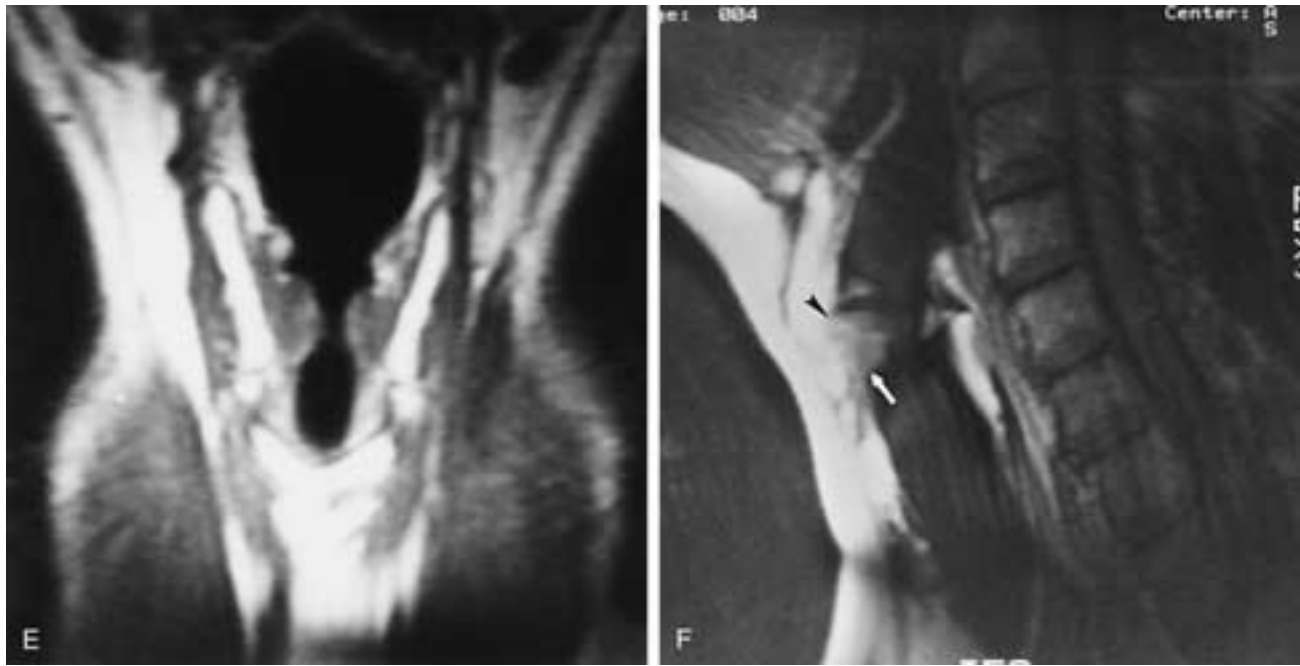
Continued.* E, Slightly posterior scan shows only slight thickening of the right true cord. F, Sagittal T1-weighted image shows a small amount of tumor (arrow) immediately inferior to the anterior commissure (arrowhead). Evaluation of tumor in this anterior part of the cord can be unreliable because of partial volume artifact.
